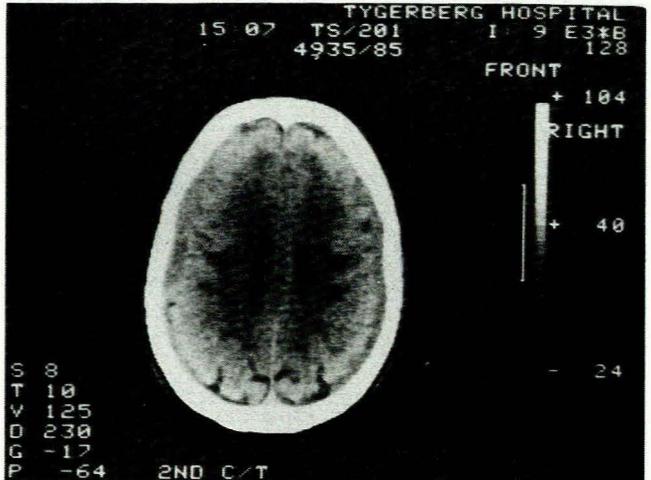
Bilateral subdural haematomas are not clearly demonstrated on a CT scan.
